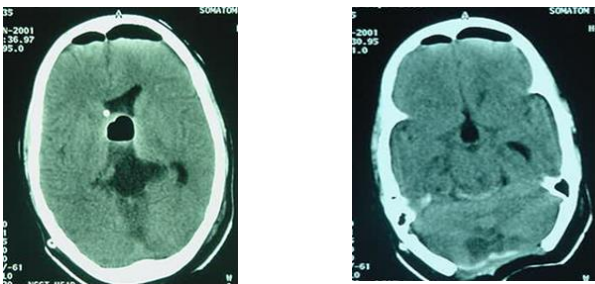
& 3D. Post-operative axial CT showing excision of pineal region epidermoid.
